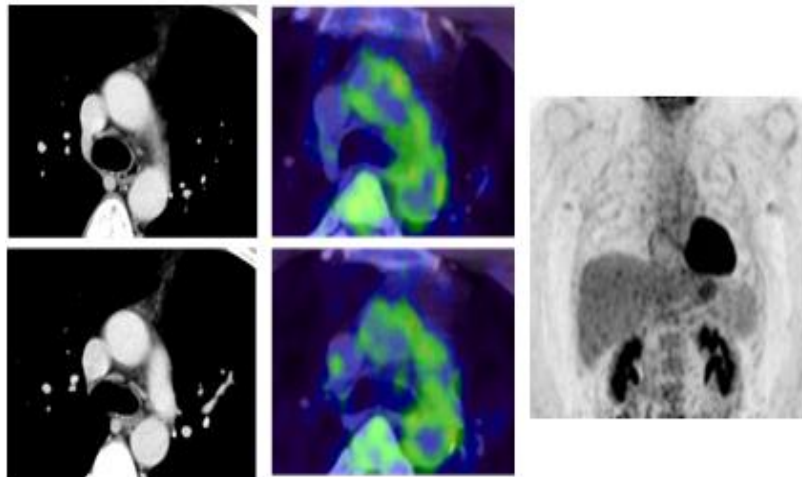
The CT and the PET 24 months after starting alectinib treatment. The therapeutic effect reached complete response (CR).
